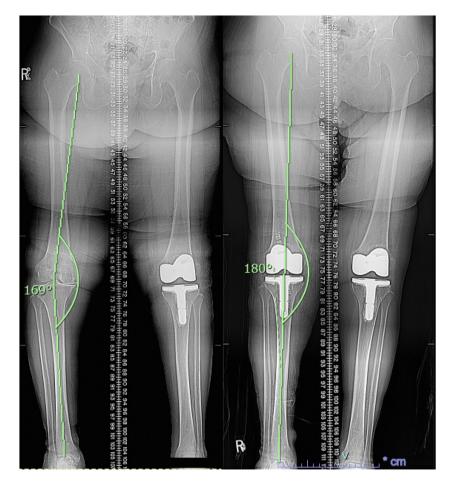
Preoperative and postoperative full-length anterior posterior radiographs of the same patient demonstrating a preoperative anatomic alignment (hip-knee-ankle angle) of 11° varus, and a postoperative anatomic alignment of 0°, prior to and following right total knee arthroplasty with conventional instrumentation. The left total knee arthroplasty was performed with conventional instrumentation and was also included in the present evaluation.
